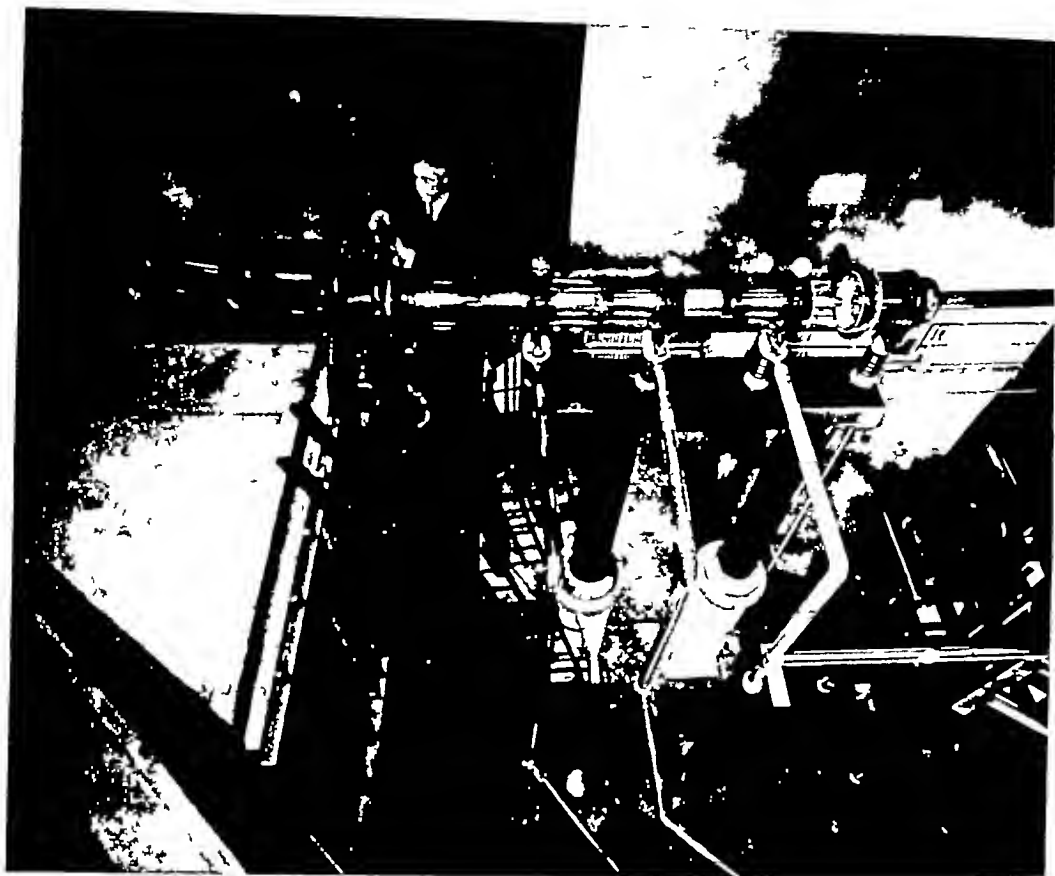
Multisectional glass walled anode grounded roentgen tube for 900 k.v pulsating, running on a continuous pump (Courtesy of General Electric X ray Corporation)
